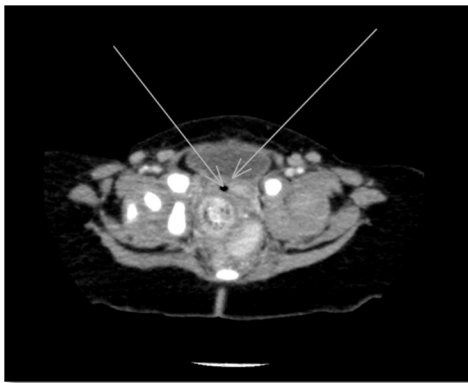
An axial enhanced CT scan imaging demonstrates a rectovaginal fistula as shown by the arrows
